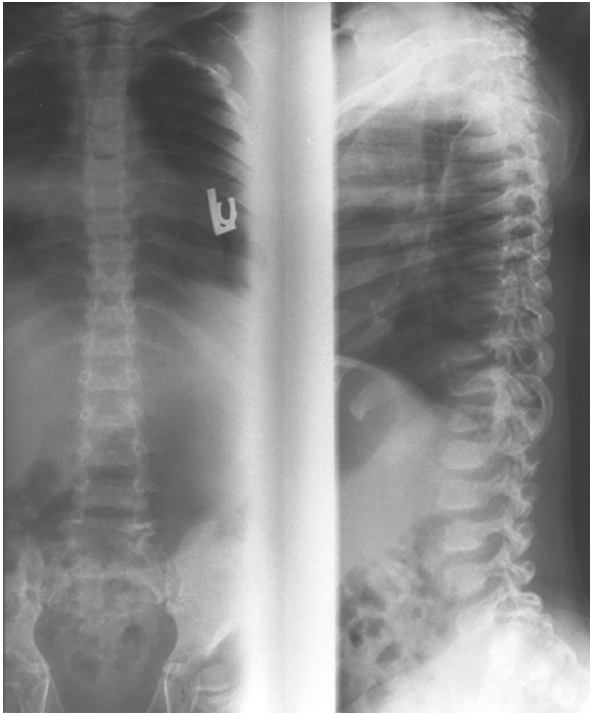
Rapidly progressing 7-year old female MPS VI patient: radiograph of spinal column showing abnormal development of vertebral bodies, paddle-shaped widened ribs, and severe lordosis.
